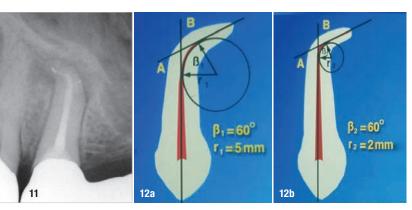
Radiograph of severely curved root canal system. Figs. 12a & b: Examples of root curvatures with the same angle but a different radius. A=; B=; $\beta=$ angle; r= radius.
